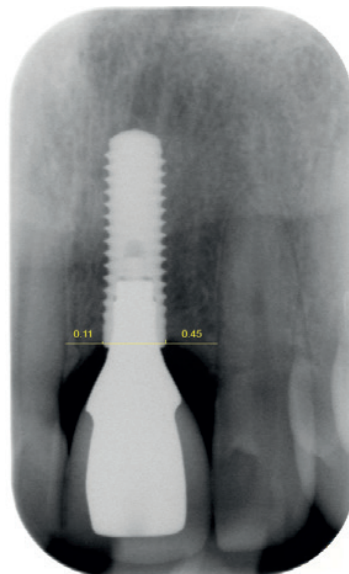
Method of measuring peri-implant bone level on an intraoral radiograph. A line was drawn from the implant shoulder to the first bone-to-implant contact on the mesial and distal side. The length of the implant body was used for calibration.
